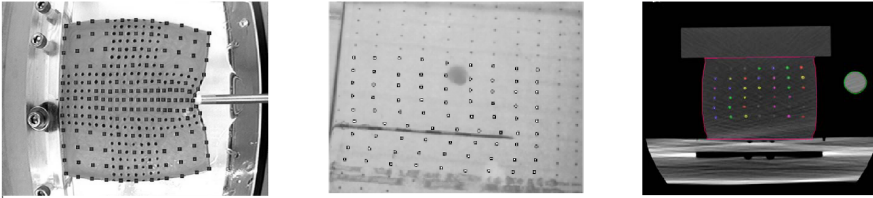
Captured images for fiducial markers tracking: Image-based marker tracking during indentation [DiMaio and Salcudean, 2003] (left), camera views with tracked fiducial markers and inserted needle [Crouch et al., 2005] (middle) and CT image of the central vertical plane of the cube in maximally uniaxial compression [Kerdok et al., 2003] (right).
